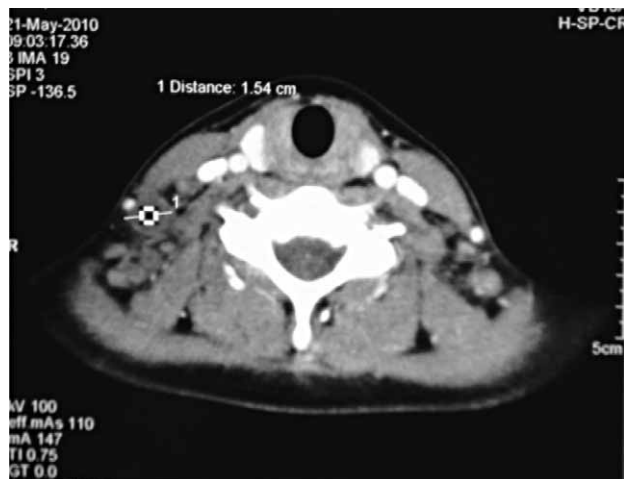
Computed tomographic (CT) scan revealed a 15 mm mass in the right lower jugular node (level IV) with peripheral enhancement.
